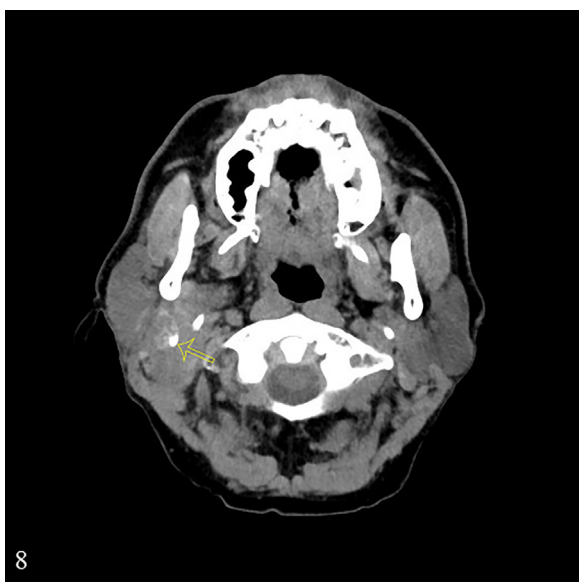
CT revealed marginal calcification around the nodule within the tumor (arrow).
